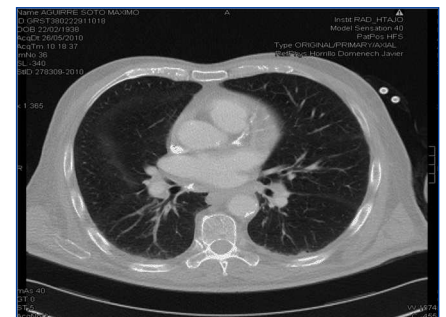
Chest computed tomography. Hilar lymph nodes.
